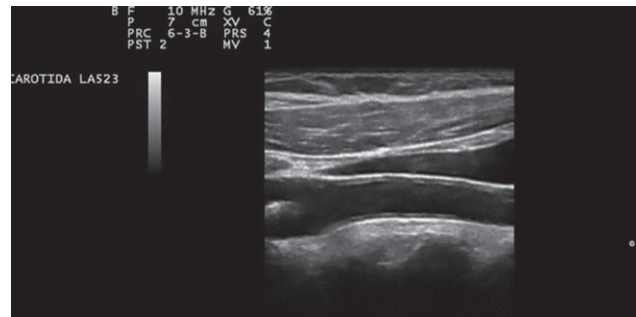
Ultrasound image of carotid intima-media thickness.
